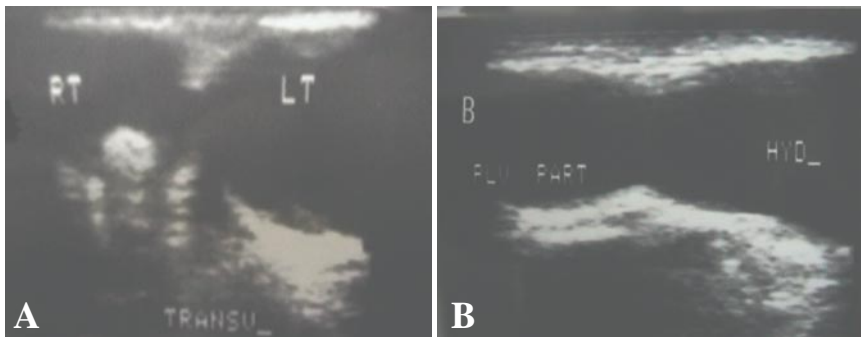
Ultrasound of the bilateral ASH
